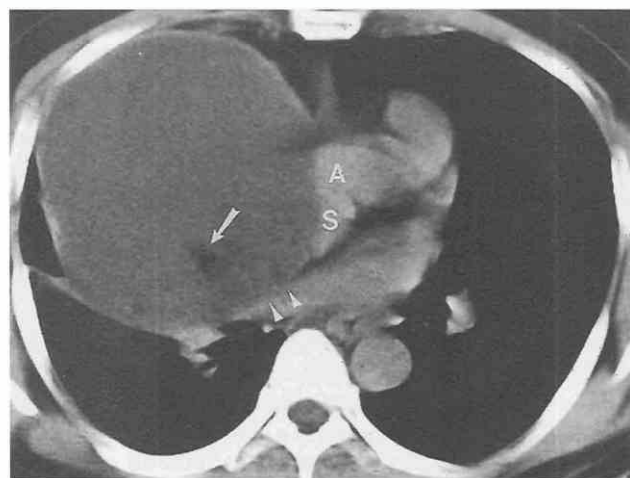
Mature teratoma. CT shows a large, predominantly water-attenuation, anterior mediastinal mass with a small focal area of fat (arrow). Mass effect can be visualized on the superior vena cava (S) and the superior pulmonary vein (arrowheads). A, ascending aorta.
